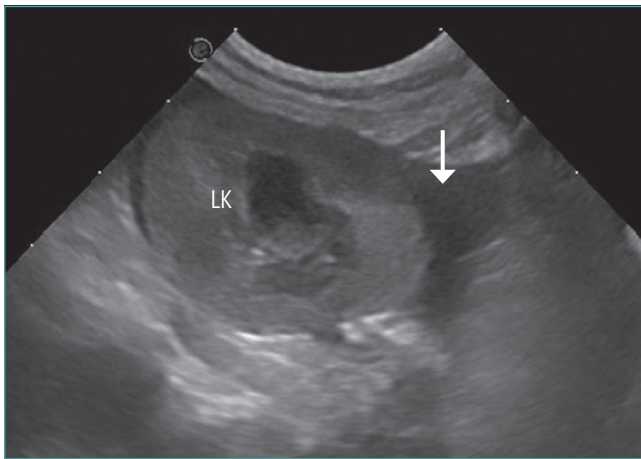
Transverse ultrasound image of the left kidney (LK) surrounded by echogenic fluid (arrow).
